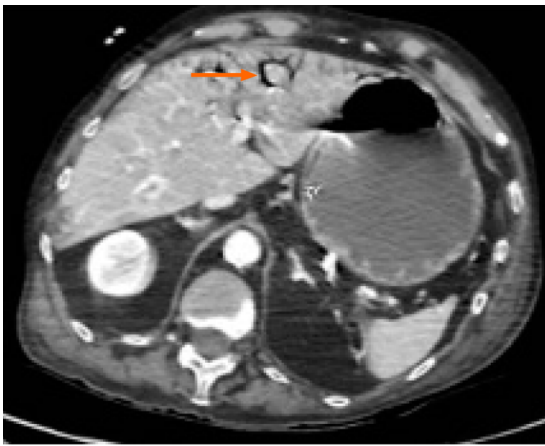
Computed tomography-scan documenting a linear pattern at the level of the colonic wall, identified by the orange arrow. (Personal observation).
